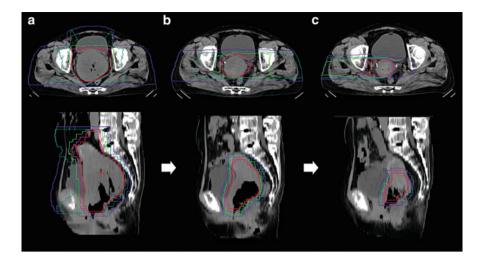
Isodose curves of CIRT for locally advanced cervical cancer (case shown in Fig. 15.2) superimposed on axial and saggital computed tomography images. (a) Whole pelvic irradiation to PTV-1: 39.0 GyE in 13 fractions. (b) Extended local boost to PTV-2: 15.0 GyE in 5 fractions. (c) Local boost irradiation to PTV-3: 18.0 GyE in 2 fractions. Total dose of 72.0 GyE in 20 fractions over 5 weeks was given to the cervical tumor. Highlighted are 95% (*red*), 70% (*pink*), 50% (*green*), 30% (*blue*), and 10% (*purple*) isodose curves
